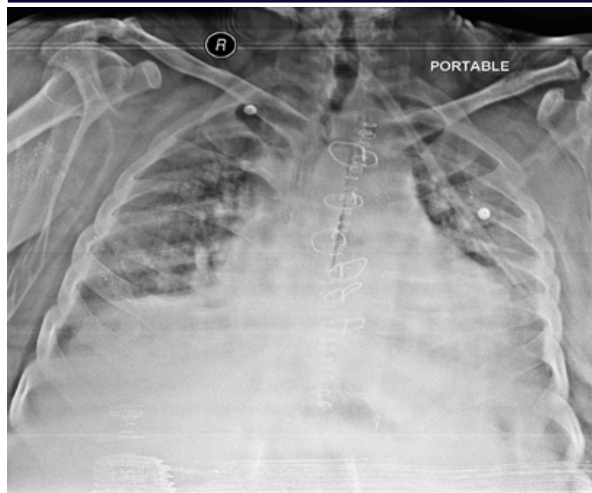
chest radiograph on POD 5, notice the malalignment of sternal wires (dancing wires)
